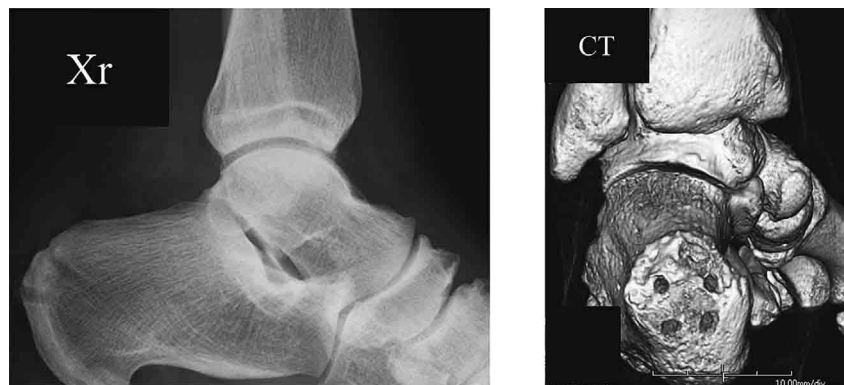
Postoperative plain radiograph and 3D-CT demonstrate appropriate resection of Haglund's deformity and the calcaneal exostosis along with complete removal of the bone fragment.
